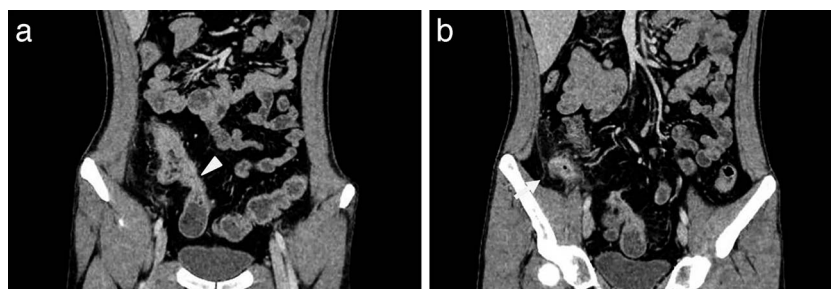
CT finding of case 1: (a) inflammation and stenosis at ileocecum, fistula (arrowhead) between terminal ileum and sigmoid colon and (b) 3 cm of intraperitoneal abscess (arrow).
